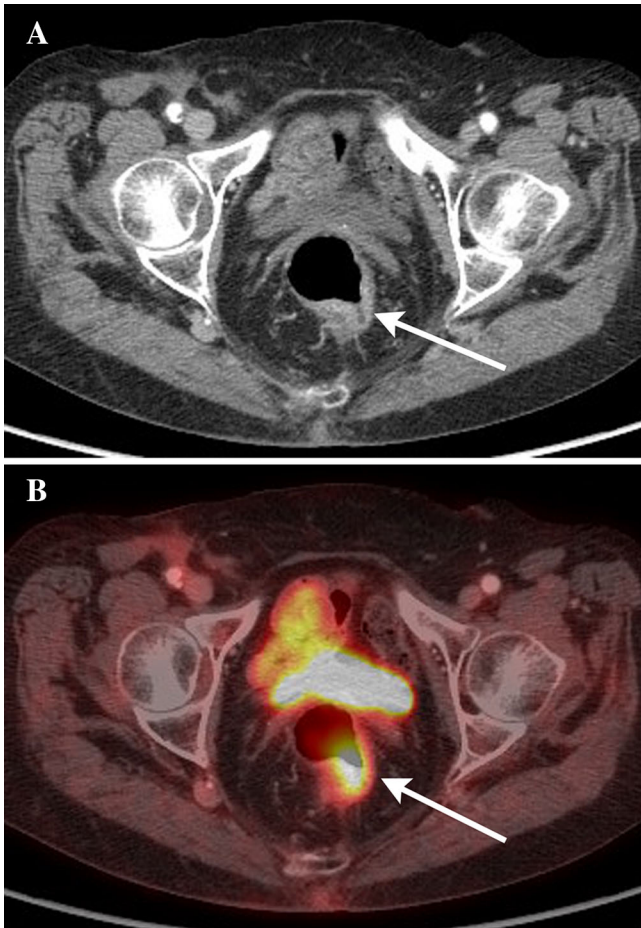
Transverse CT (A) and PET (B) images in a 60-year-old male with isolated recto-sigmoid colitis without associated diverticulosis. There is colonic wall thickening, mucosal hyperenhancement, and pericolic inflammatory change isolated to the recto-sigmoid colon (*white arrow*). There is no associated colonic diverticulosis.
